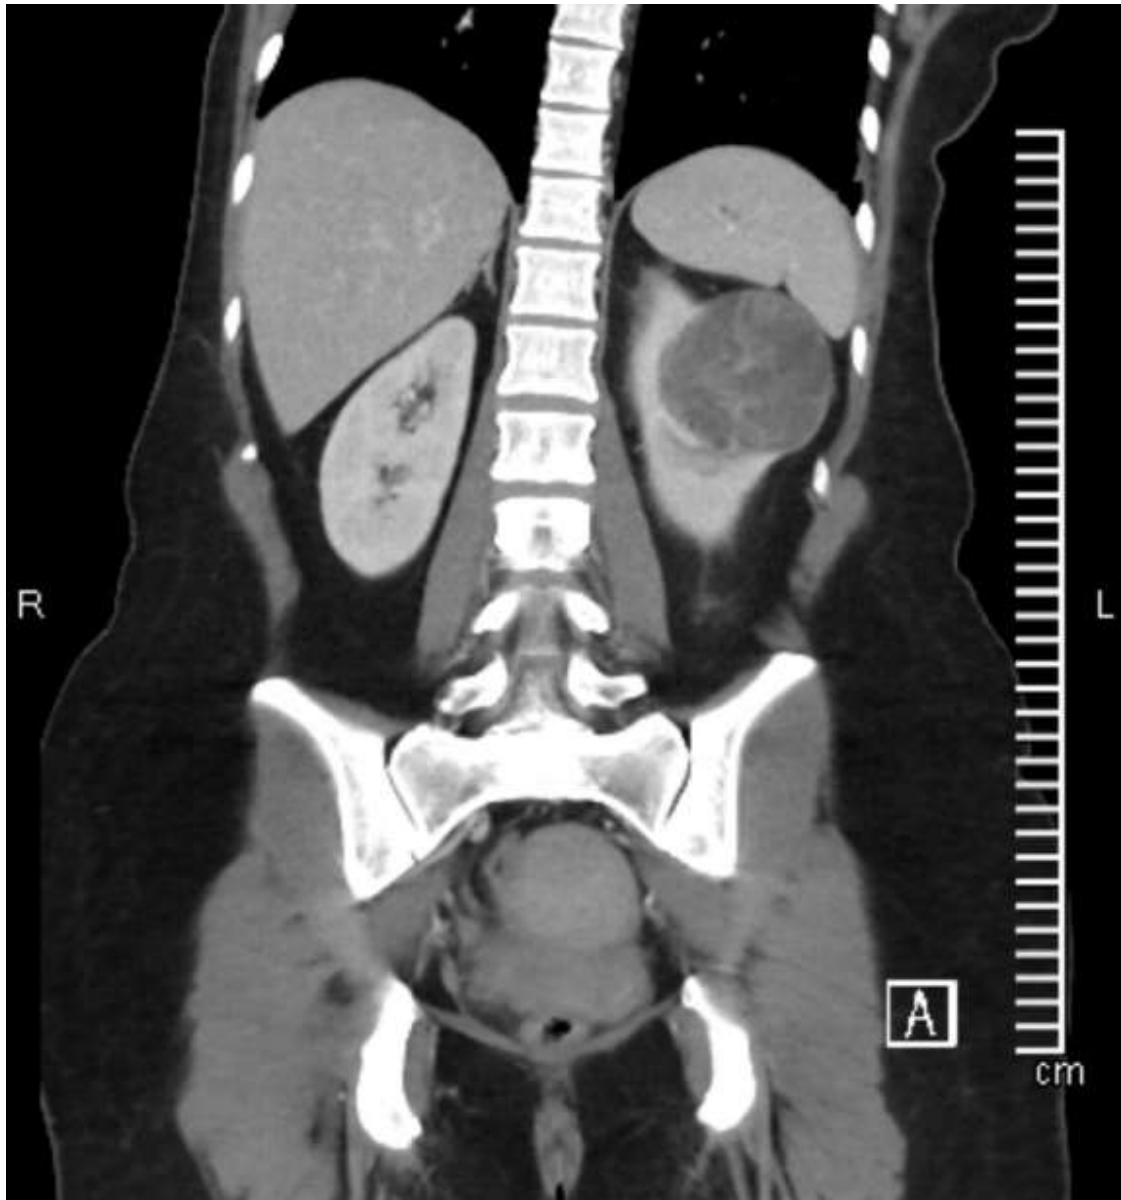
Computed tomography (CT) scan of the abdomen and pelvis in (A) axial and (B) coronal views revealing a left-sided kidney mass radiographically consistent with a renal cortical neoplasm and indistinguishable from renal cell carcinoma. Region of interest (ROI) attenuation value on unenhanced CT was 20.0 HU. After intravenous contrast administration, ROI attenuation value was 48.2 HU.
